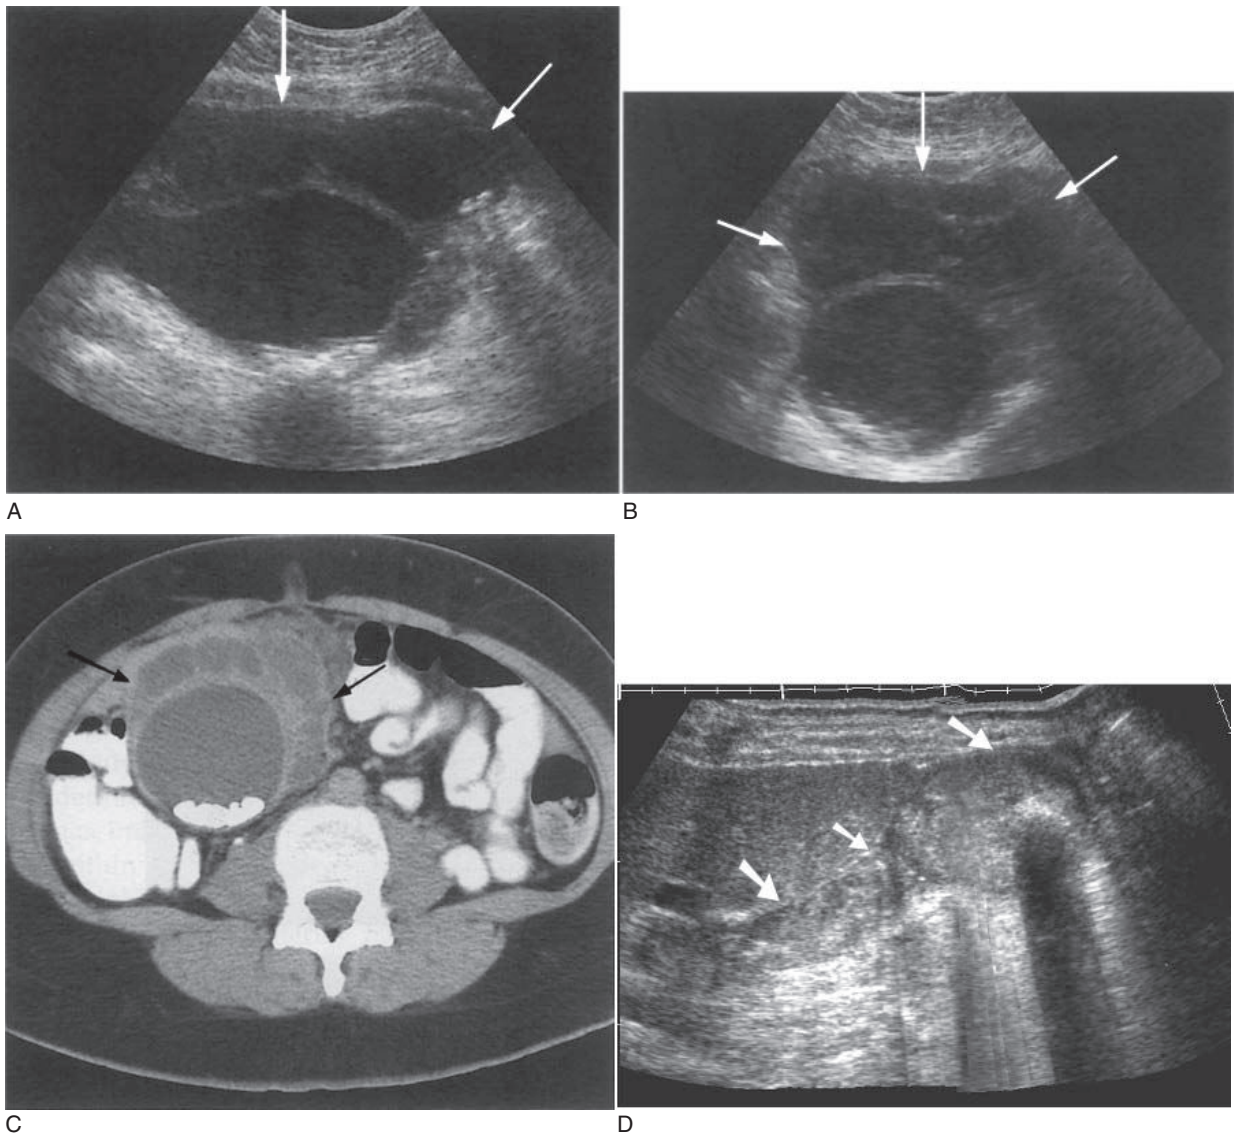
Gallbladder empyema. (A) and (B) LS and TS of the same gallbladder. The gallbladder has ruptured, forming a cholecystoenteric fistula which had resealed at surgery. The gallbladder contains pus and stones, with several anterior septations, forming pockets of infected bile which also contained stones (arrows). (C) CT scan confirming the ultrasound appearances. (D) Gallbladder empyema demonstrating a large gallbladder full of pus and stones.
